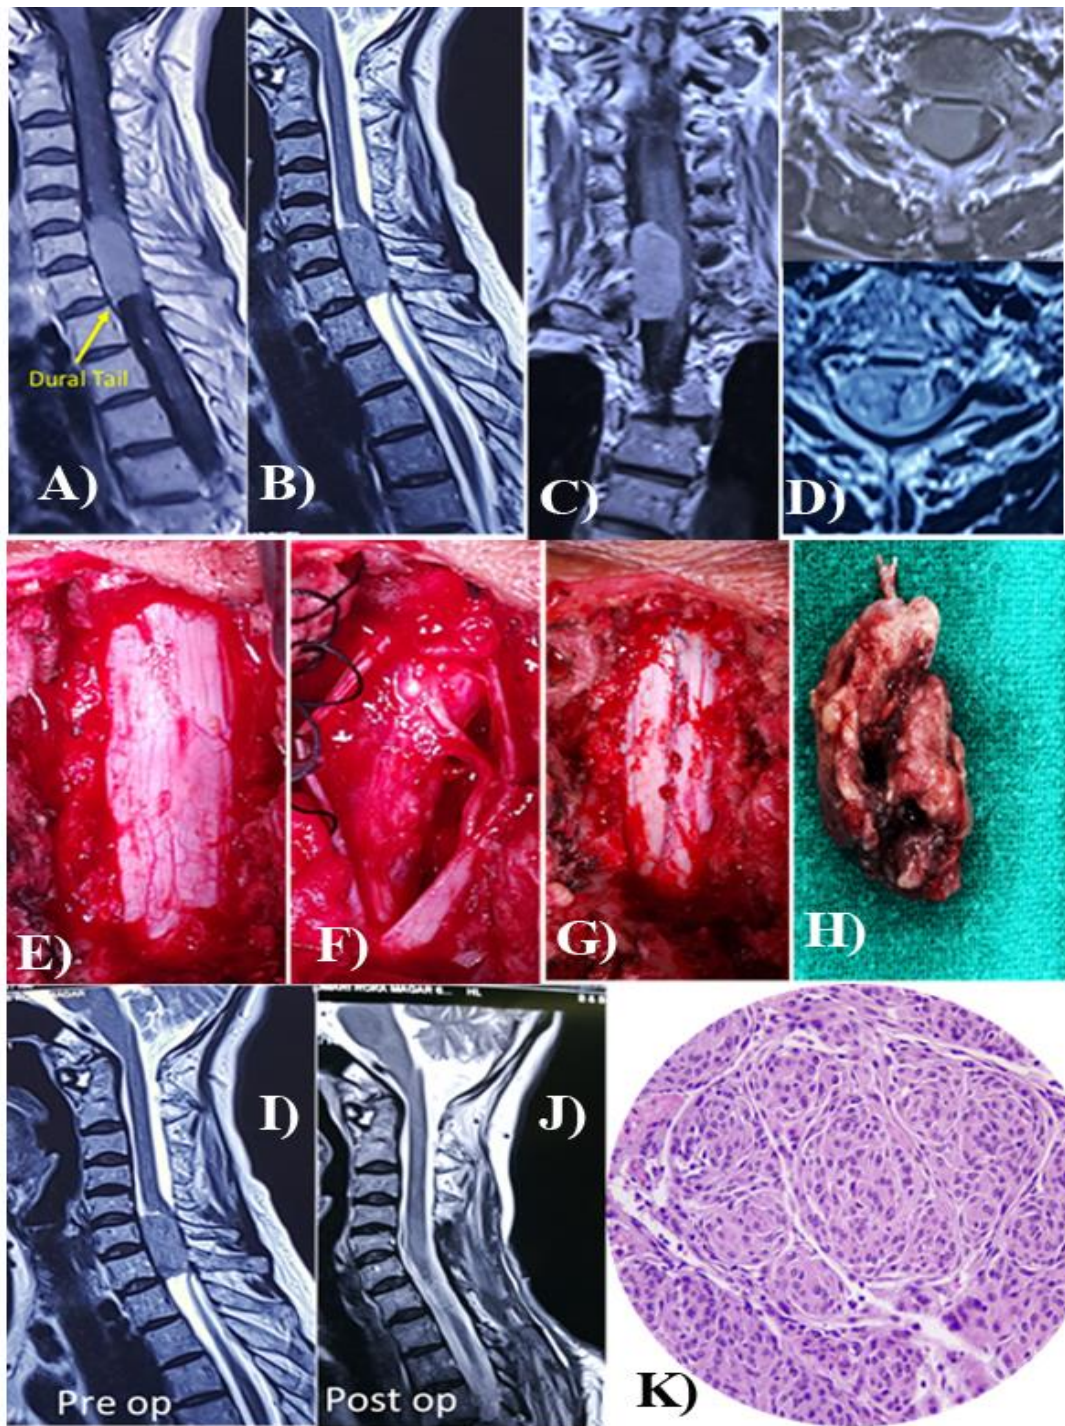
Meningioma: (A, B) Preoperative sagittal T1, T-2 weighted, and T1 coronal MRI showing the hypo intense lesion; (C, D) Preoperative axial T1 Weighted Image and post-contrast T-2 weighted image showing the partially enhanced tumor and severely compressed spinal cord (E-H)Intraoperatively image showing tumor resection; (I, J) Pre and Postoperative sagittal T-2 weighted MRI showing radical tumor resection); (K) Biopsy of the same lesion showing typical lobulated whorl pattern of cellular growth typical of meningioma.
